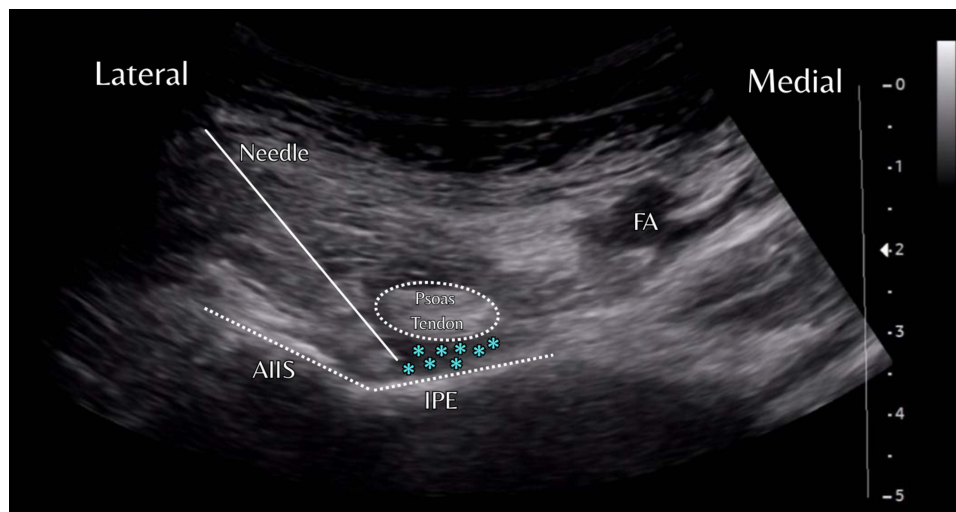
Ultrasound-guided PENG block. The block was performed using an in-plane lateral-to-medial approach. The block needle is shown as a continuous white line. A white dotted circle surrounds the psoas tendon. White dotted lines identify the anterior inferior iliac spine (AIIS) laterally and the iliopectineal eminence (IPE) medially. Blue asterisks indicate the spread of local anesthetic between the psoas tendon—visibly elevated following injection—and the IPE. The depth scale on the right side of the image indicates the depth at which the block was performed.
